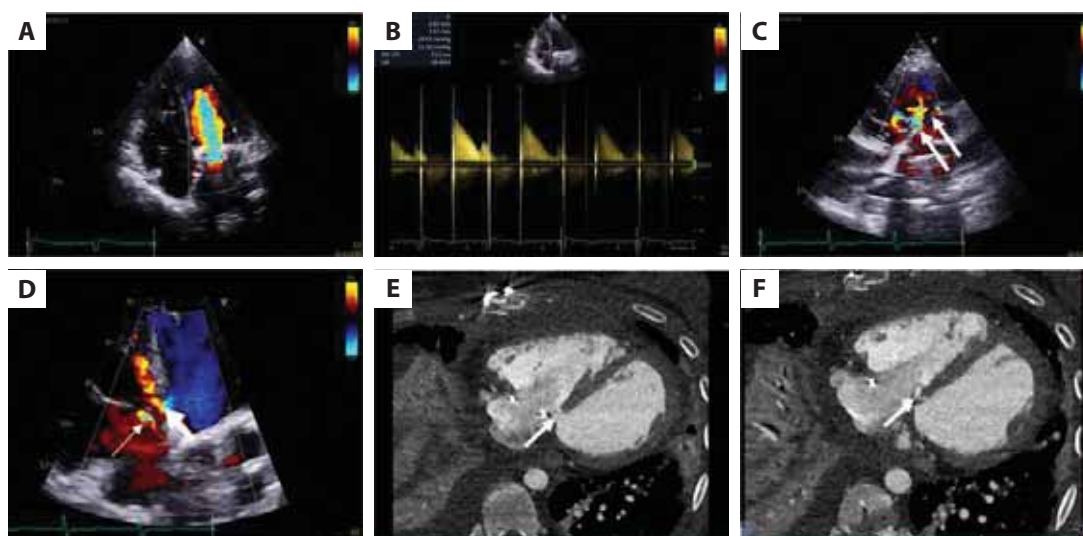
A. Transthoracic echocardiography. Apical four-chamber view. Color flow Doppler. Turbulent flow through mitral mechanical mitral prosthesis. B. Transthoracic echocardiography. Continuous flow Doppler signal. Elevated gradients through mechanical mitral prosthesis reaching 28.4 mm Hg of maximum and 11.2 mm Hg of the mean pressure gradient. C. Transthoracic echocardiography. Parasternal short-axis view. Two ruptures in the muscular part of the ventricular septum with left-to-right shunts (the arrows). D. Transthoracic echocardiography. Apical four-chamber view. Left-to-right shunt through one of the ventricular ruptures (wide arrow), tricuspid regurgitation (the narrow arrow). E. Cardiac computed tomography. Axial view. One of the ventricular septum ruptures (the arrow). F. Cardiac computed tomography. Axial view. The second of the ventricular septum ruptures (the arrow)
